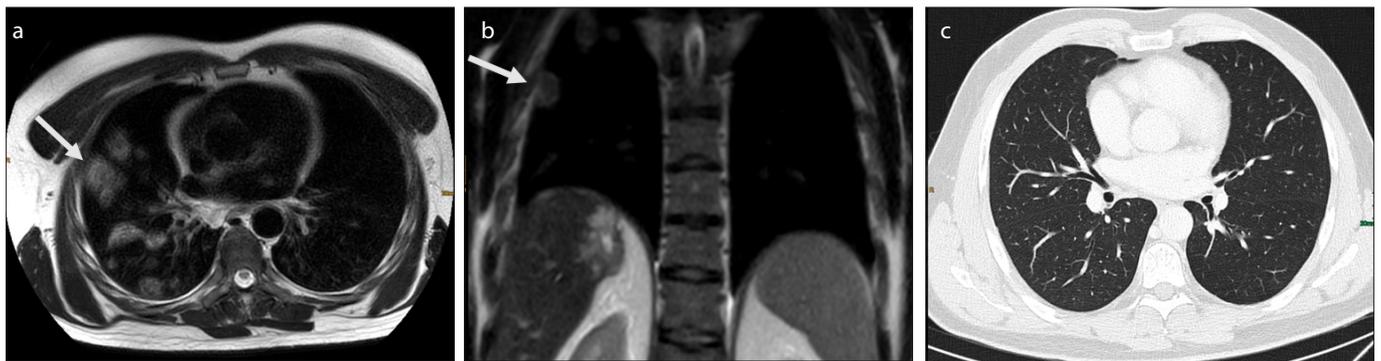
a–c. MRI of a patient with COVID-19 infection. Transversal (a) and coronal (b) T2-weighted images show multilobar distributed focal lesions (a, b, arrow), which appeared recently compared with a CT scan acquired 2 months earlier (c).
